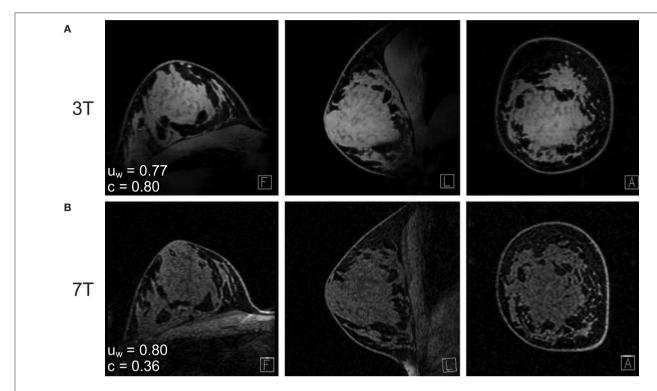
Fat-suppressed T₁-weighted MRI of the same subject at (A) 7T and (B) 3T. The water signal uniformity (u_w) is similar across 3T and 7T, while the fat-water contrast (c) is markedly improved at 7T. Reprinted with permission from Brown et al. (28); © 2013 Wiley Periodicals, Inc.
